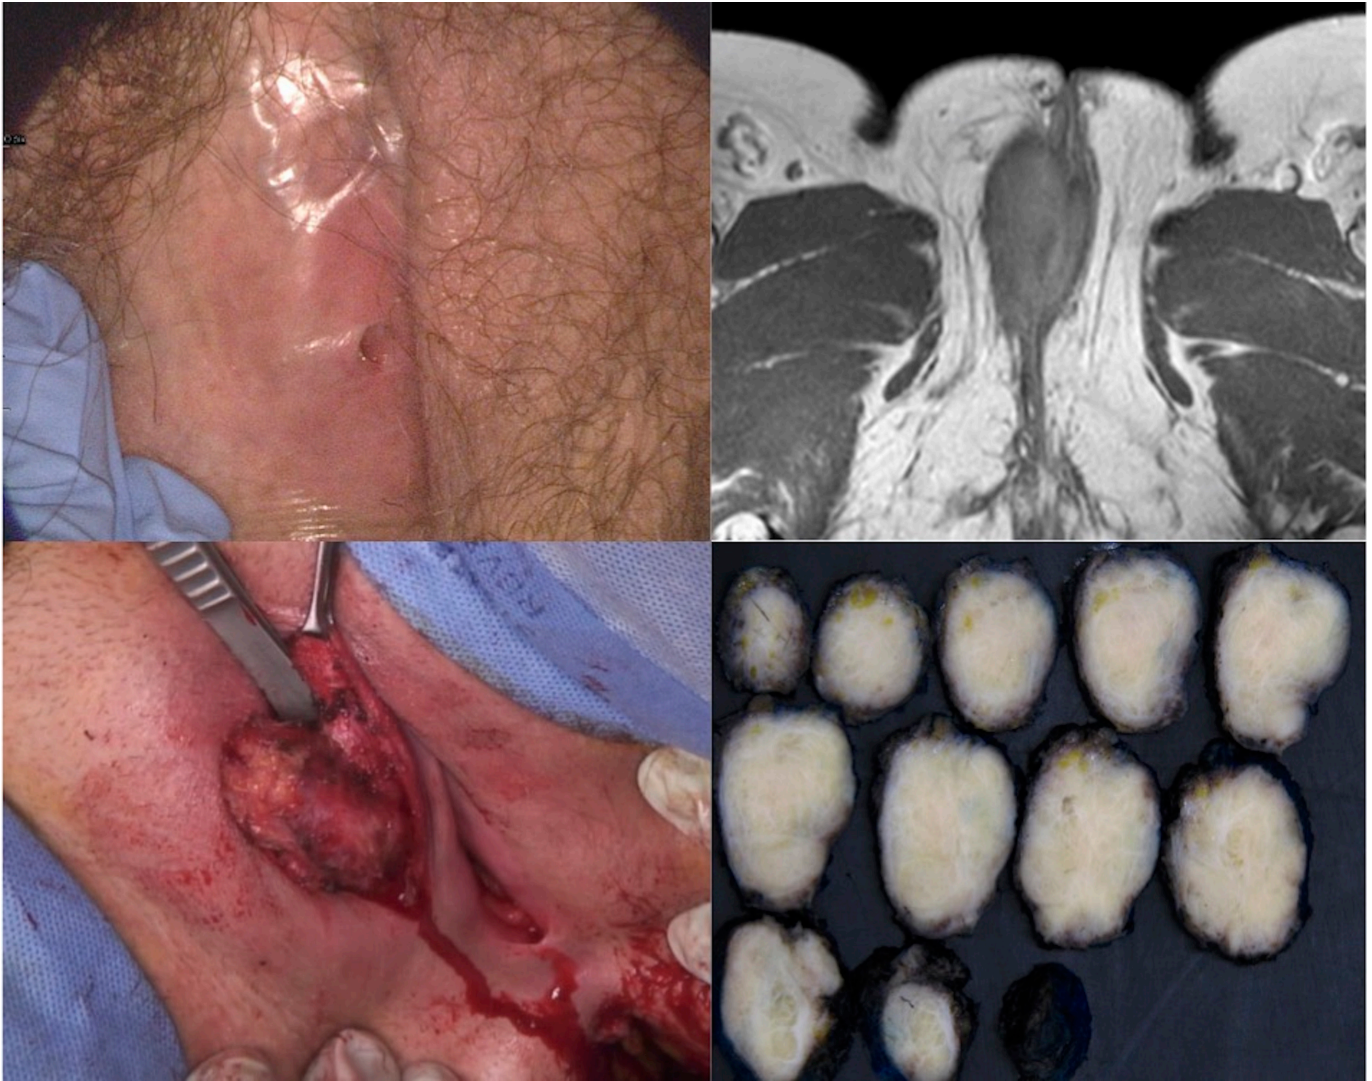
The clinical, radiological, operative and pathological findings of the GCT. Right sided labium majus lesion on initial colposcopic examination (arrow) (Top Left). MRI Pelvis noting right labium majus mass (arrow) (Top Right). Operative appearance of the labial mass (arrow) (Bottom Left). Macroscopic appearance of the lesion noting tan tissue measuring 52 × 28 × 20 mm with a pale and whorled cut surface (Bottom Right) (Colour image).
